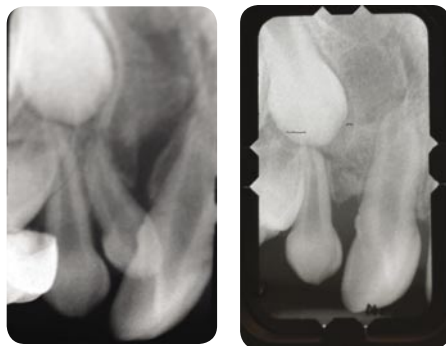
Pre- and postoperative radiograph showing the bone formation.
